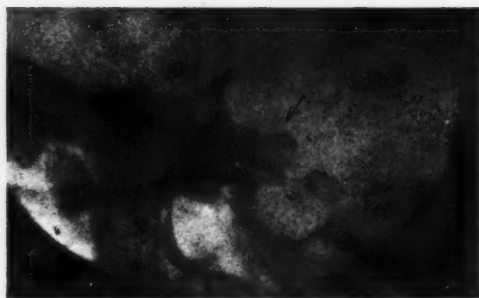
Lateral roentgenogram of the sella turcica. One anterior clinoid process is thickened, bulgy, and of irregular contour. (The same case as Figure 17.)
